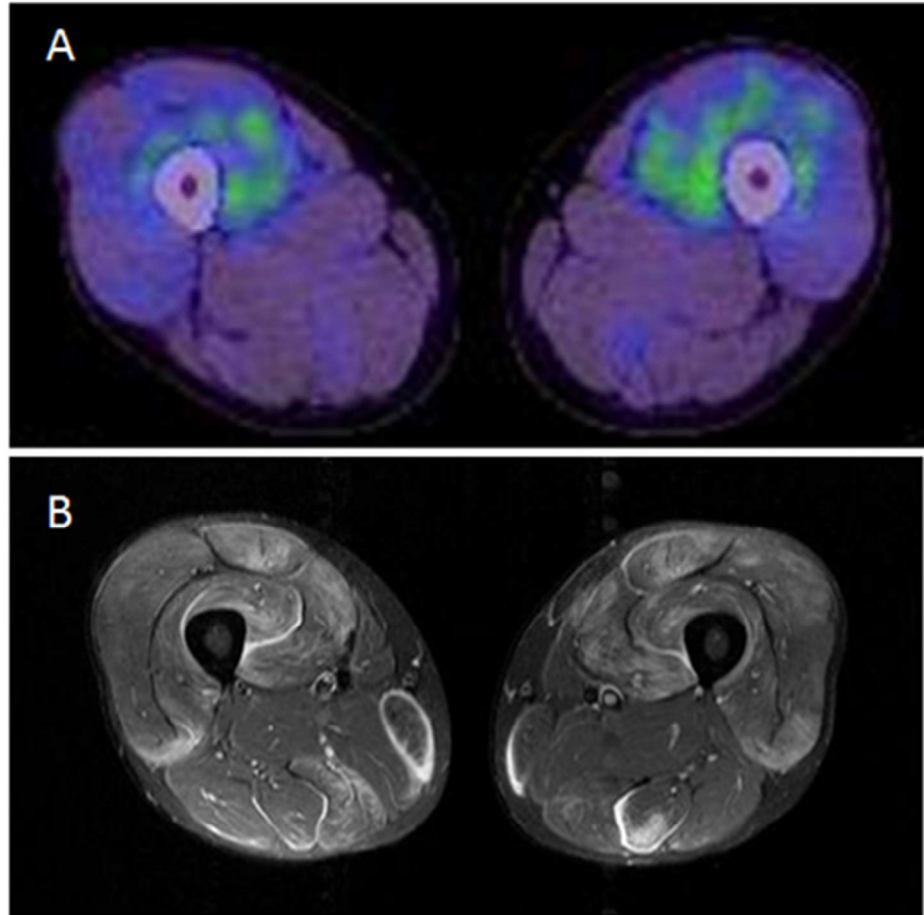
FDG PET (A) and MRI findings (B) of thighs in a patient with PM (Patient 14). In MRI, muscles show a diffuse high signal. In contrast, FDG uptake is more localized and predominantly inside of the muscles.
